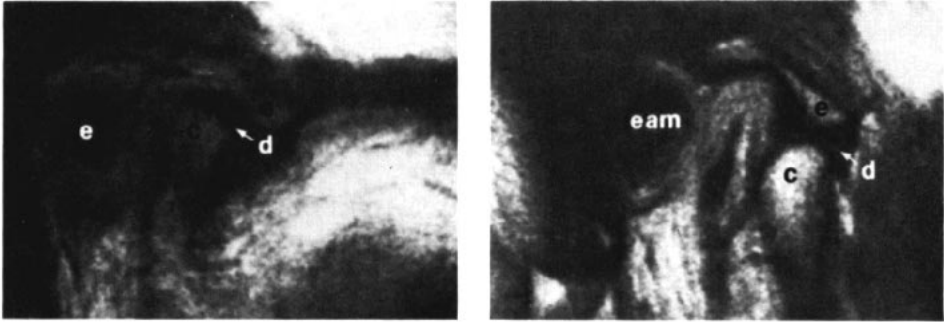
MRI of a normal TMJ. The external auditory meatus (eam) appears as a relatively large black area. The central area of the condyle (C), is directly anterior to the meatus and appears white because of the fatty bone marrow contained within it. The periphery of the condyle is covered by articular cartilage and cortical bone on sagittal view. Both are relatively devoid of water, emit a low signal intensity, and appear as black bands. The articular eminence (e) and the black fibrocartilagenous disc (d) can also be seen.
